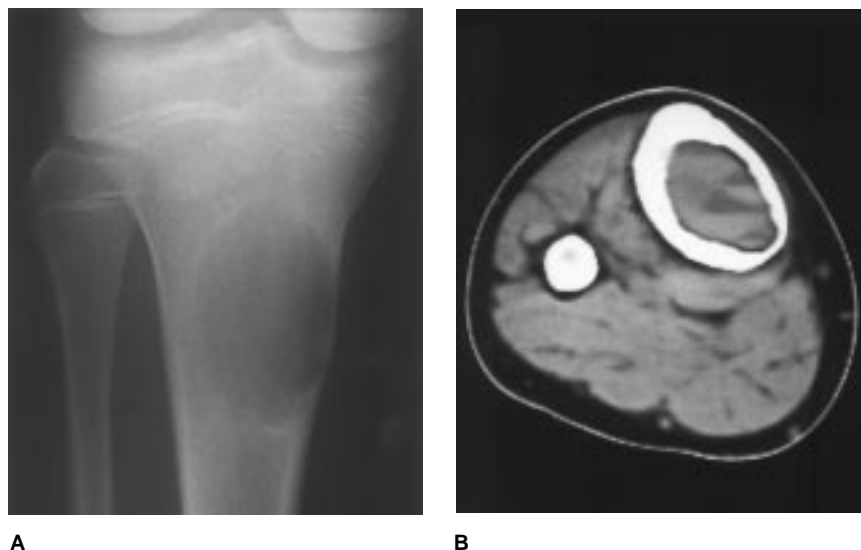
A, The lesion seen on this plain radiograph is most consistent with a unicameral bone cyst, although it could represent fibrous dysplasia or a nonossifying fibroma. B, On this CT scan the radiolucent lesion has the density of fluid (measuring markers are not shown on this photograph), indicating a cystic lesion. The only reasonable diagnosis that would be consistent with the plain radiographic and CT appearance is a unicameral bone cyst.
